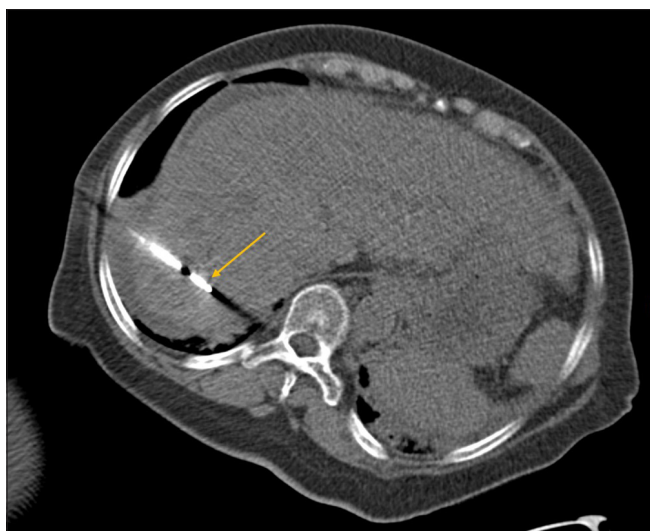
The same 62-year-old man with cirrhosis complicated by diuretic-resistant ascites, found to have hepatocellular carcinoma during workup for transjugular intrahepatic portosystemic shunt. Computed tomography fluoroscopy spot image showing microwave ablation probe placement in the liver (orange arrow) before ablation through the ascites plane obviating the need for transpulmonary approach.
